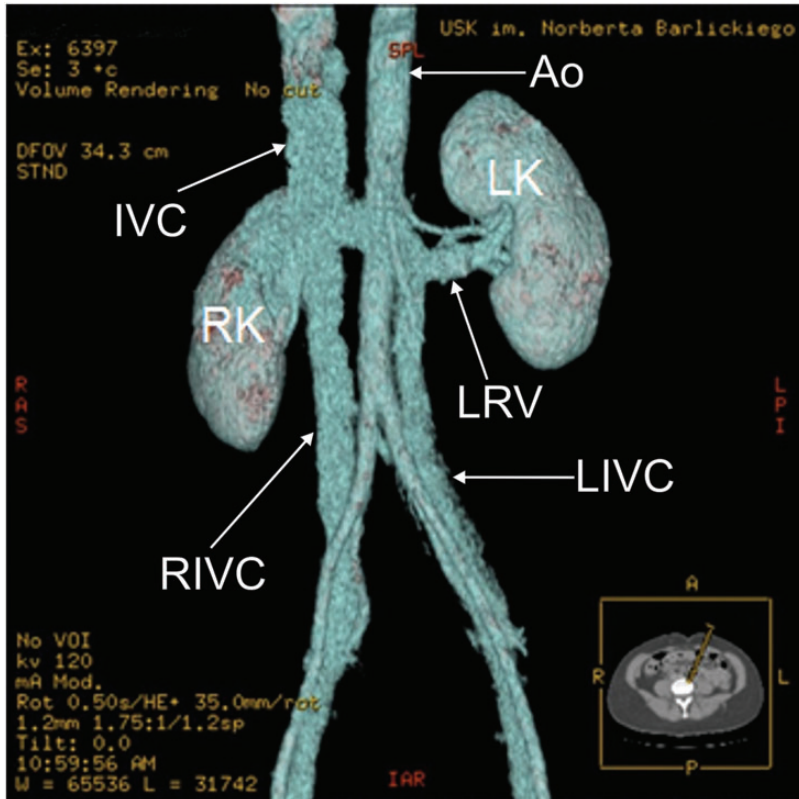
Three-dimensional computed tomography (CT) reconstruction of the abdomen vessels based on late arterial phase CT, showing the inferior vena cava (IVC), abdominal aorta (Ao), right inferior vena cava (RIVC), left inferior vena cava (LIVC), left renal vein (LRV), left kidney (LK), and right kidney (RK).
